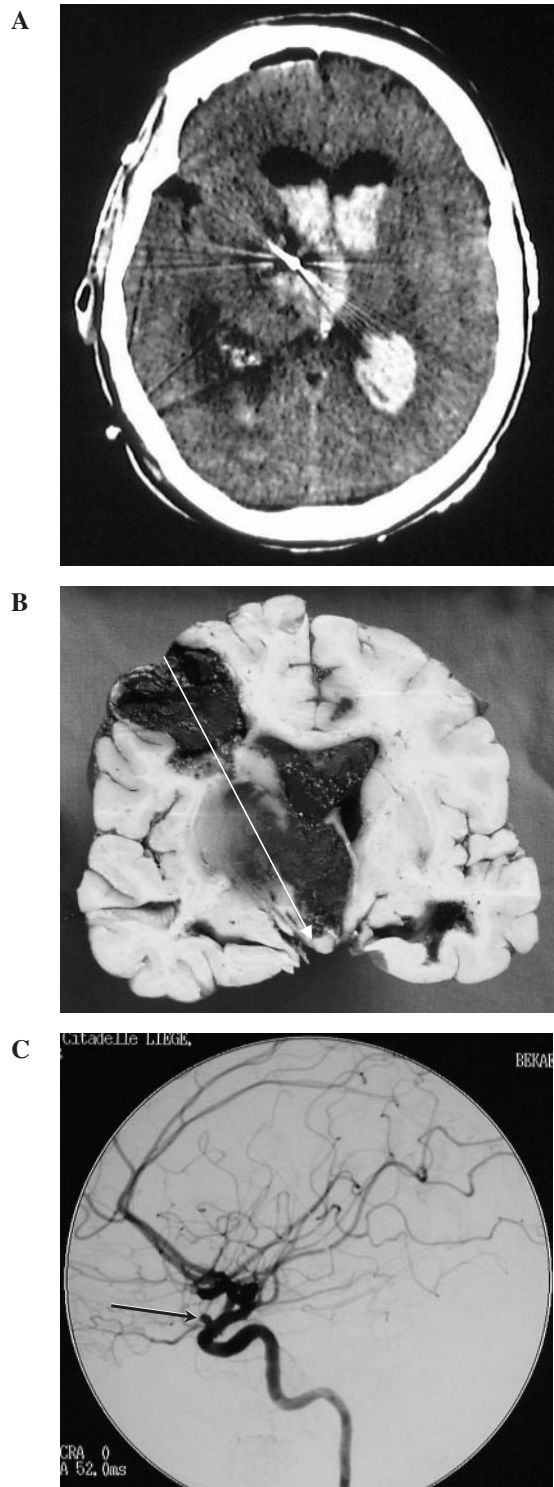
Patient 6. (A) CT scan 6 h after electrode implantation showing left deep intracerebral haemorrhage around the electrode artefact and blood in both lateral ventricles. (B) Coronal section of formalin-fixed brain at the level of the posterior hypothalamus. Note swollen left hemisphere, basal ganglia haemorrhage, intraventricular blood and a superficial haematoma at the entry site of electrode implantation. The arrow indicates the approximate position of the stimulating electrode. (C) Digitized angiography 18 h after electrode implantation, showing a saccular aneurysm of the supracavernous portion of the left carotid artery (arrow).
